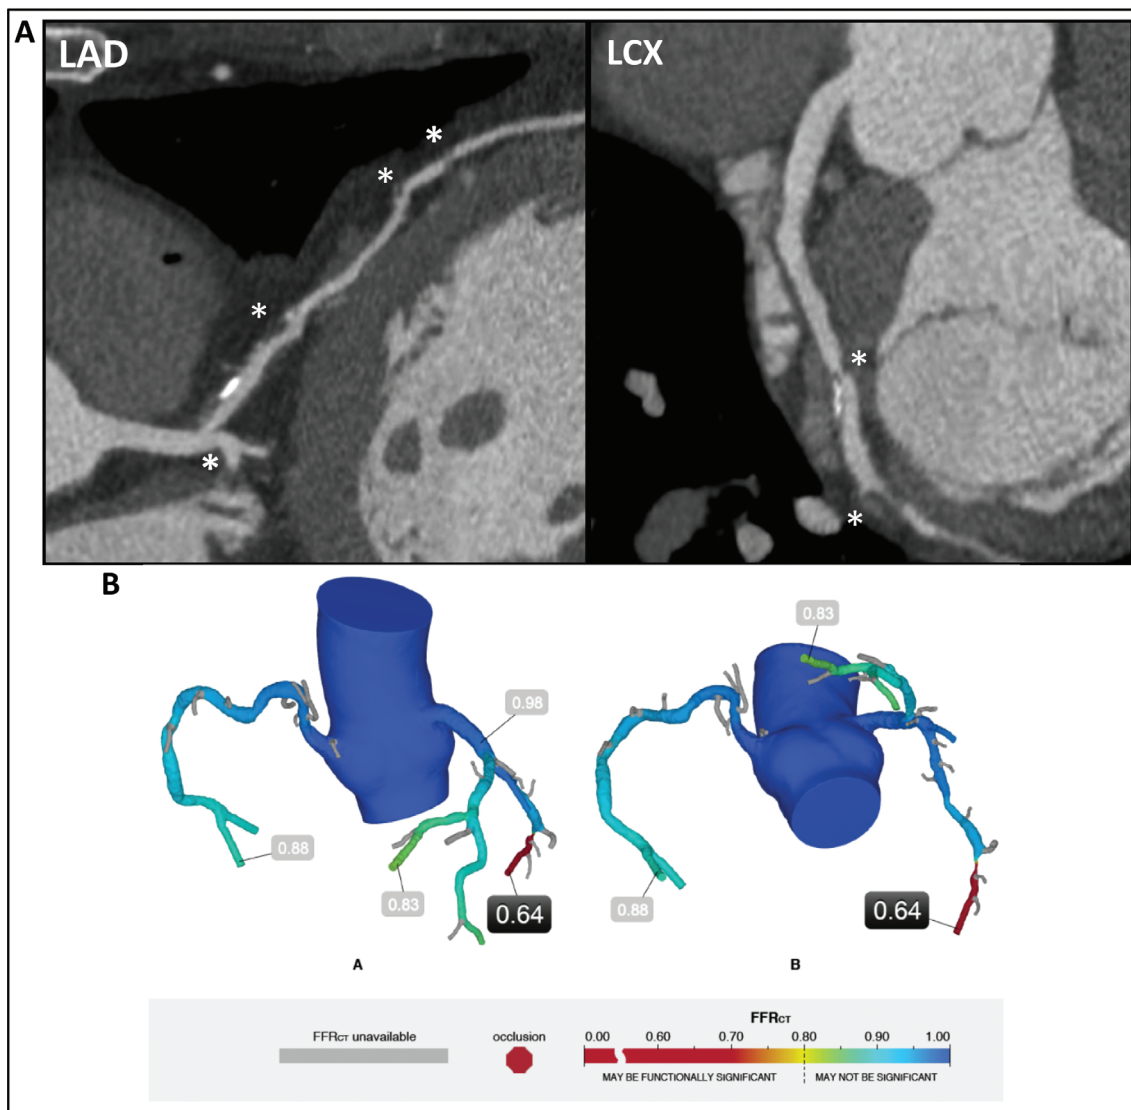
An Example Case of Coronary Computed Tomography Angiography (CCTA) and CCTA-derived Fractional Flow Reserve.
